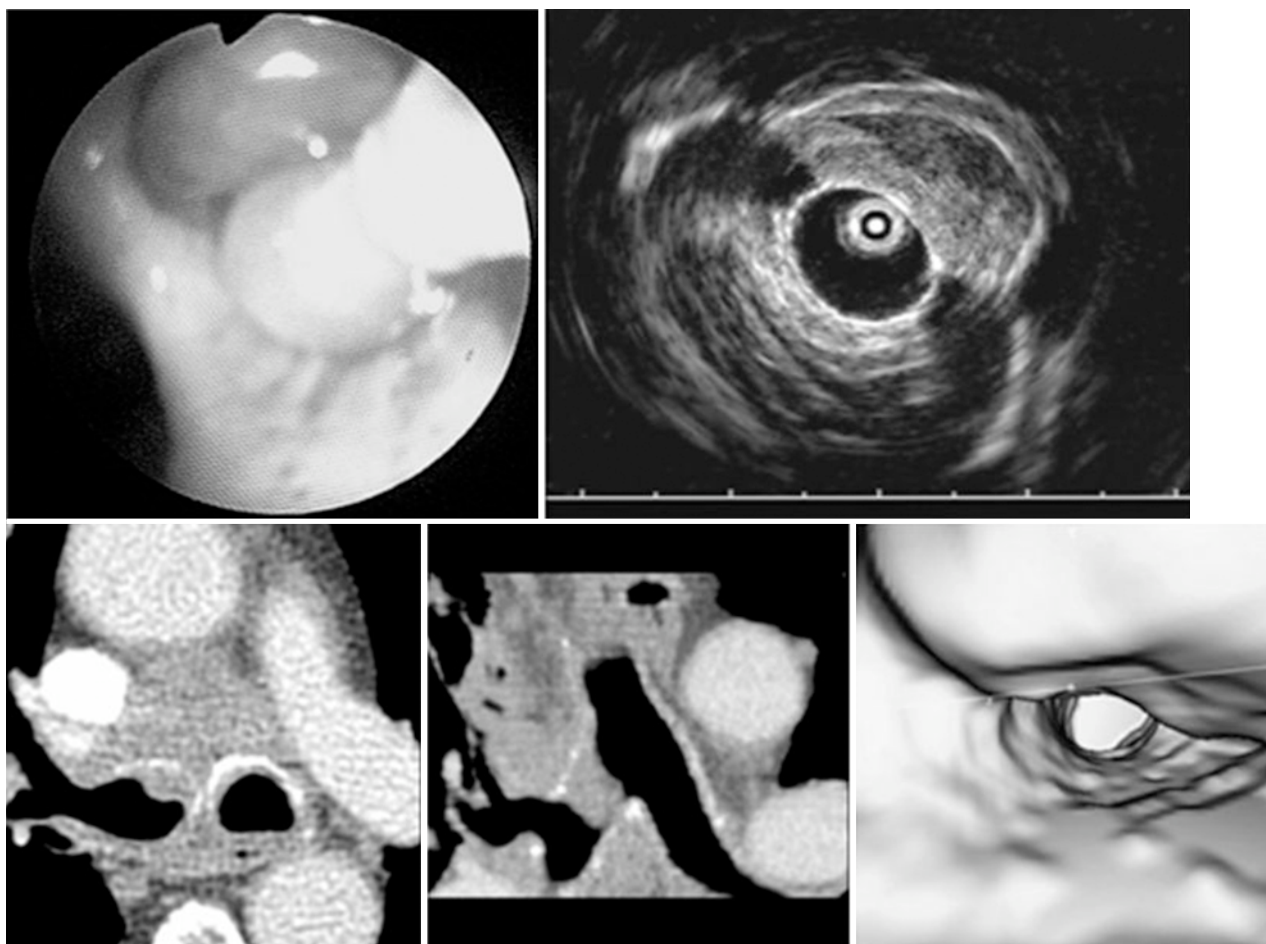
59-year-old patient (patient #22) with a small-cell carcinoma in the right main bronchus. Endoscopy (upper left): The exophytic tumor at 12 o'clock, using the EBUS probe. Sonography (upper right): Detection of the solid, low-echo mass. The tumor is infiltrating the bronchial wall. Primary axial MSCT slices (lower left), coronal multiplanar reconstruction (center) and virtual bronchoscopy (lower right) yield a comparable image of the tumor.
